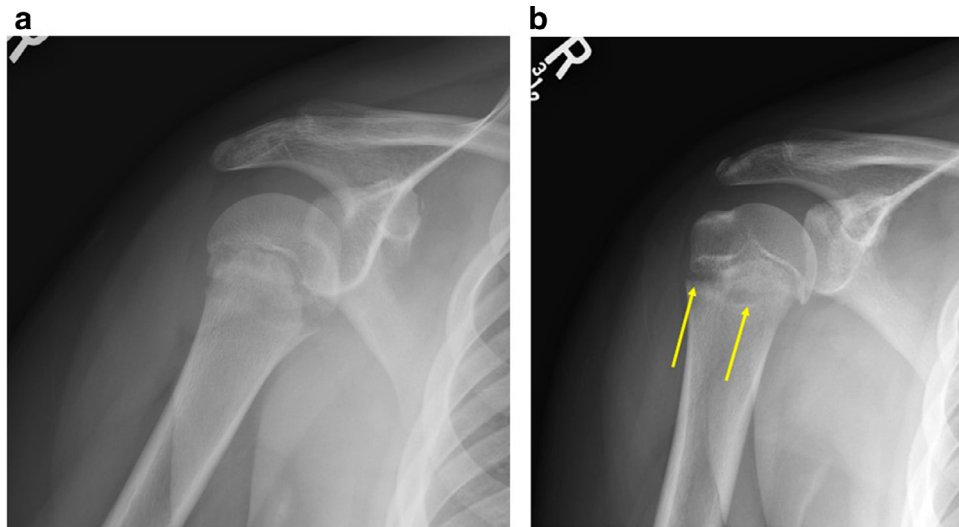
Internal (a) and external (b) right shoulder radiographs on a 12-year-old pitcher with insidious onset of shoulder pain demonstrating the imaging hallmark of a chronic Salter-Harris I stress injury or fracture. The arrows highlight the widened growth plate. Contralateral radiographs were not needed to make the diagnosis in this case.
